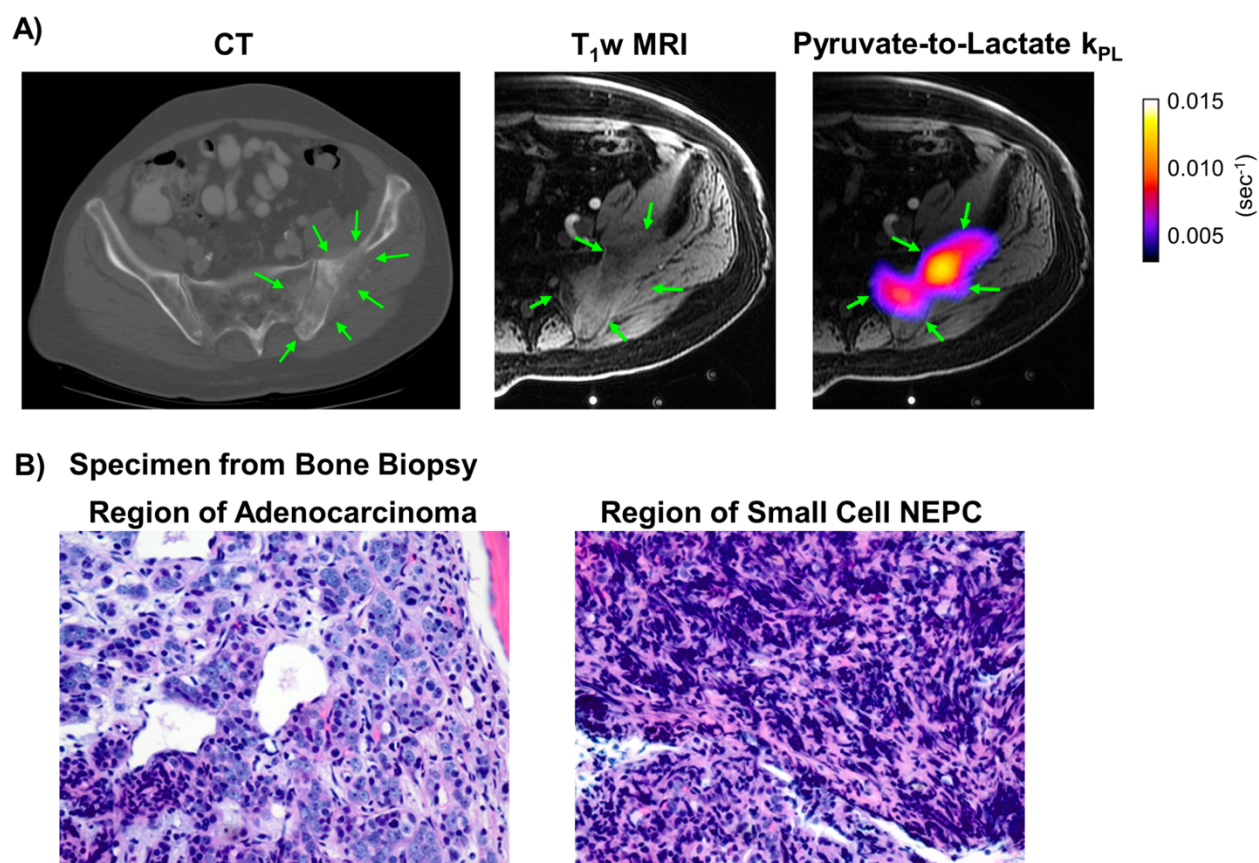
(A) Patient 1 (75 years old) was diagnosed with metastatic castration-resistant prostate cancer with several large osteoblastic lesions throughout the left hemipelvis and involving left femur. CT identified a relatively osteolytic lesion in left ilium (green arrows), measuring 9.9×4.1 cm. The lesion was infiltrative, causing destruction of the bone cortex and extension into the surrounding soft tissues. T₁-weighted (T₁w) spoiled gradient-echo MRI was used to target the same lesion observed on CT for the HP ^{13}C MR acquisition. Regions of high pyruvate-to-lactate conversion rate (k_{PL}) correlated with the osseous lesion on CT and hypointensity on T₁w MRI. k_{PL} was estimated 0.013 (s^{-1}). (B) The paired bone biopsy demonstrated discrete regions of adenocarcinoma and treatment-emergent small cell neuroendocrine differentiation.
